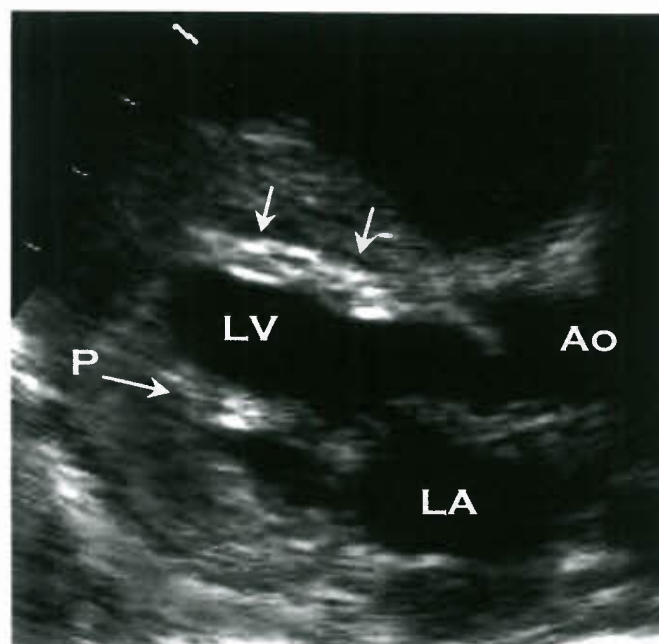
Echocardiographic parasternal long-axis image in an infant with critical aortic stenosis demonstrating severe endomyocardial fibroelastosis (double arrows) and infarcted papillary muscle (P). LA, left atrium; LV, left ventricle; Ao, aorta.
